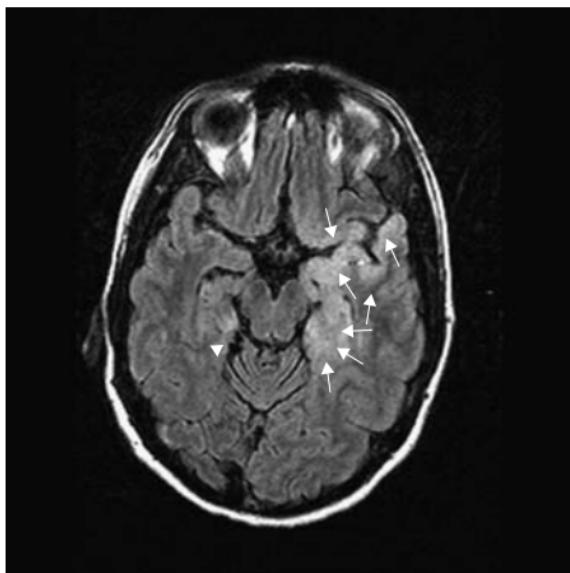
HSV encephalitis. (a) Axial T2W and (b) axial FLAIR MRI. Ill-defined hyperintensity with gyral expansion involving the anterior and medial aspects of the left temporal lobe, including the amygdala and hippocampus, and inferior portion of the left frontal lobe and insular cortex ((a) white arrowheads and (b) white arrows). Asymmetric bilateral temporal lobe involvement is typical. Note the subtle involvement of the right medial temporal lobe ((b) white arrowheads). Gyriform enhancement and haemorrhagic change are common.
